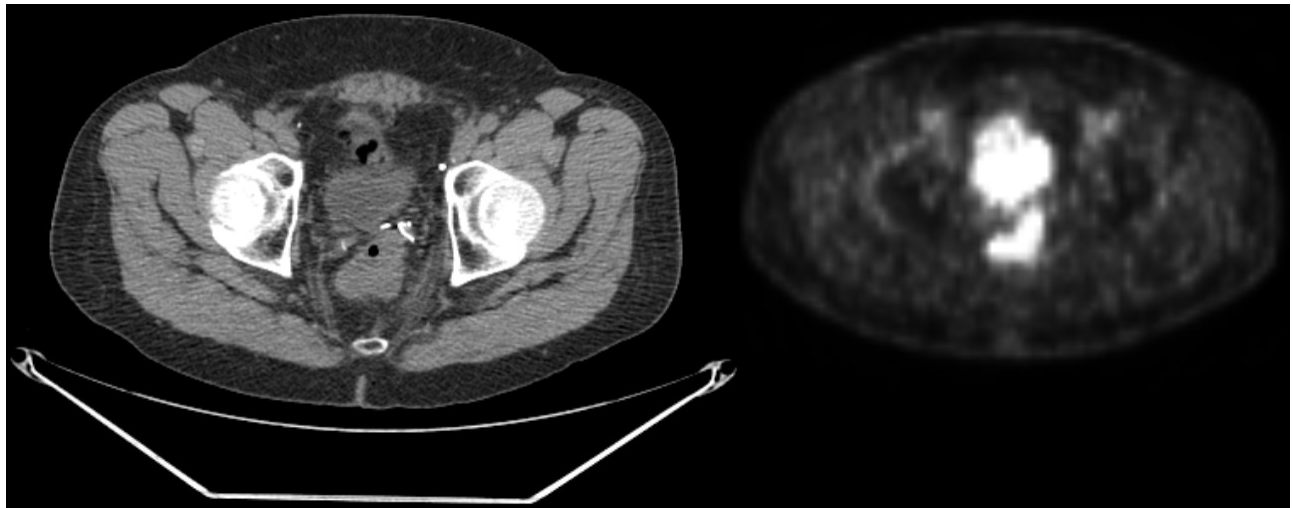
A single image from a joint PET/CT scan acquired for one of the patients in the study. CT scan is on the left, and PET scan is on the right.
